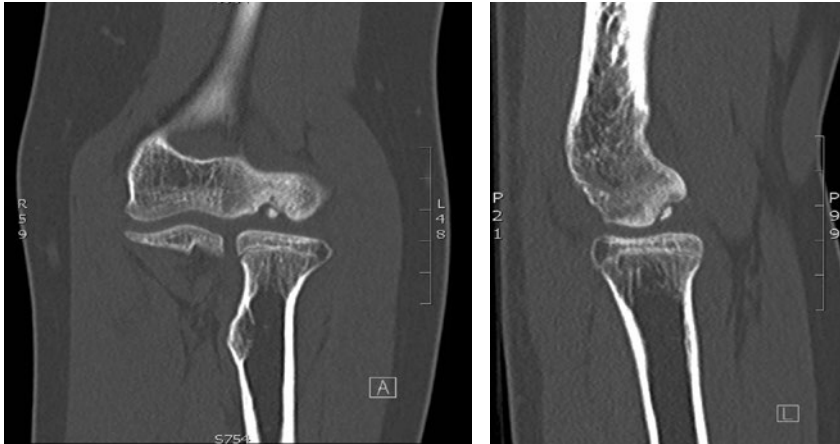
Coronal (A) and sagittal (B) CT-scan images of an osteochondral defect of the capitellum of the *right* elbow in a young girl with osteochondritis dissecans.
